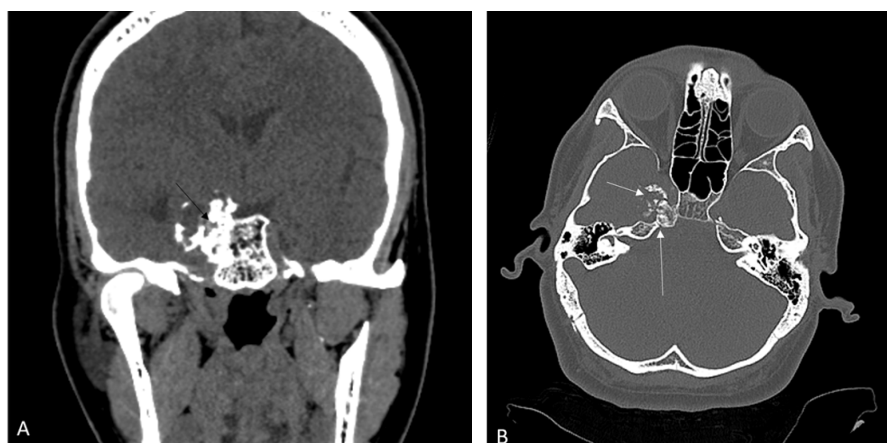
Coronal bone window (A) and axial soft tissue window (B) images from non-contrast CT of the brain demonstrate a large mass protruding from the body of the sphenoid (black arrow). Underlying calcifications in the form of 'rings and arcs' are noted (short white arrow). Note the petroclival synchondrosis which appears intact (long white arrow).
